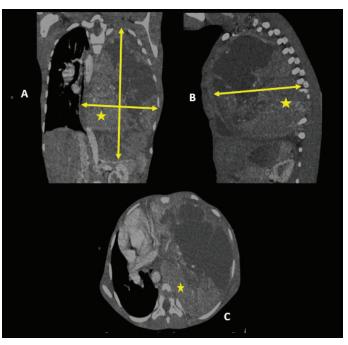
Contrast-enhanced coronal (A), sagittal (B) and axial (C) images of chest CT in the mediastinal window. showing a solid-cystic mass lesion with inhomogeneous enhancement filling the entire left hemithorax and displacing the mediastinum to the right side (double arrow). Solid portion was localized mainly along the postero-inferior part of the lesion (star).
